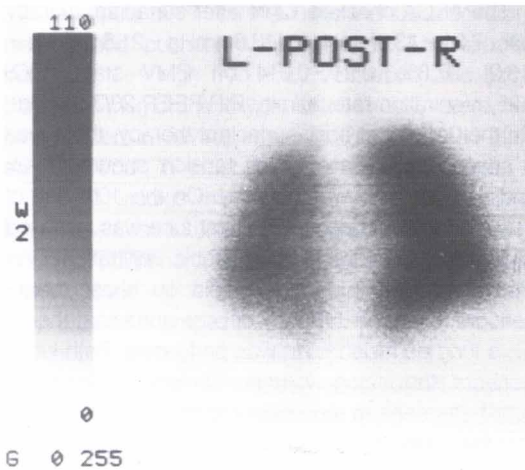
The lung perfusion scan obtained on the 14th day of post-surfactant therapy showed that there were the same volume of both lungs showing radioisotope uptake as seen in the chest roentgenogram.
